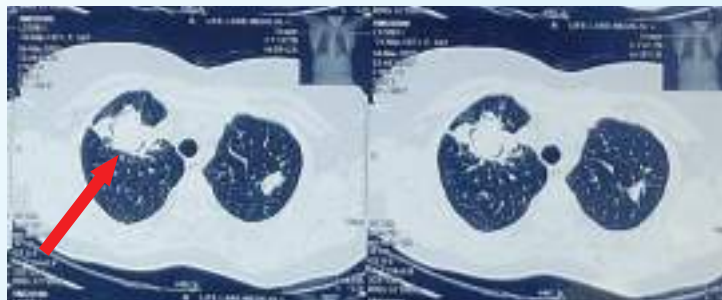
Initial CT chest showing pulmonary aspergilloma at right upper lobe
